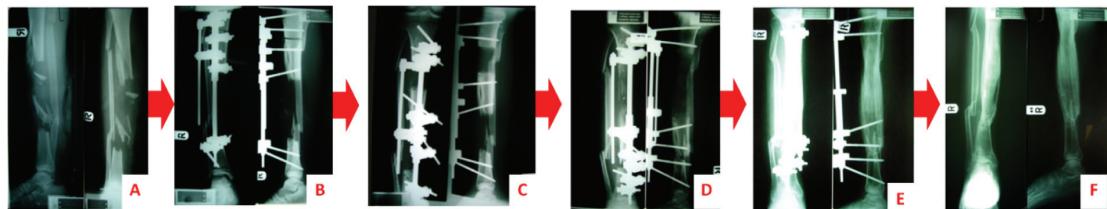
The radiographic of a patient with open tibial fracture type IIIA with bone loss 14 cm
